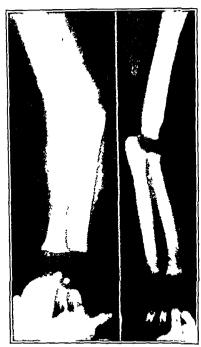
Case 3. Roentgenogram of arms at 512 months of age. The cortex of the long bones is thickened, especially in the midpart of the diaphyses.
